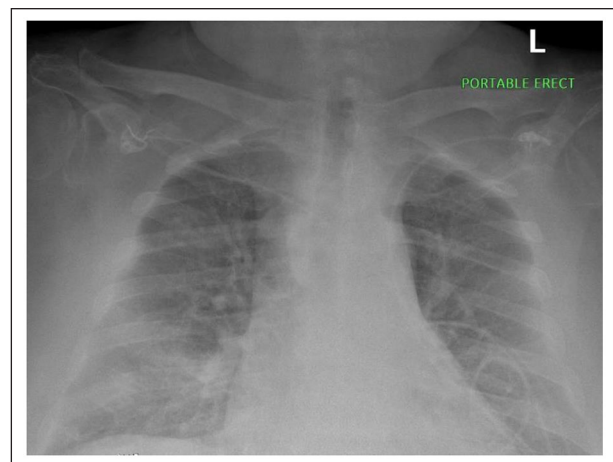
The chest X-ray showed multifocal bilateral patchy interstitial and alveolar infiltrates. No pneumothorax was present. Findings were consistent with multifocal bronchiolitis pneumonia consistent with the history of COVID-19 pneumonia.
